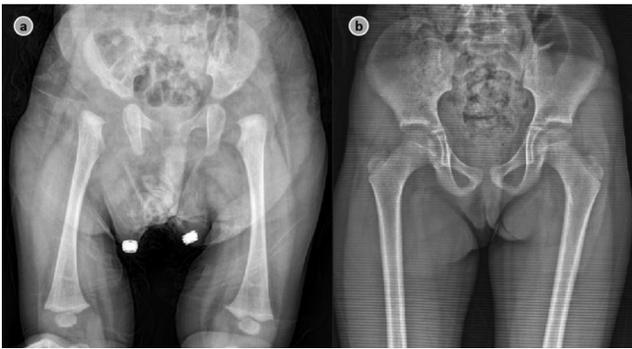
Radiographic views of bilateral hips undergoing MOR. AP radiographs of a 10-month-old female with bilateral DDH before and 9 years following anteromedial open reduction DDH: Developmental dysplasia of the hip, AP: Anterior posterior
